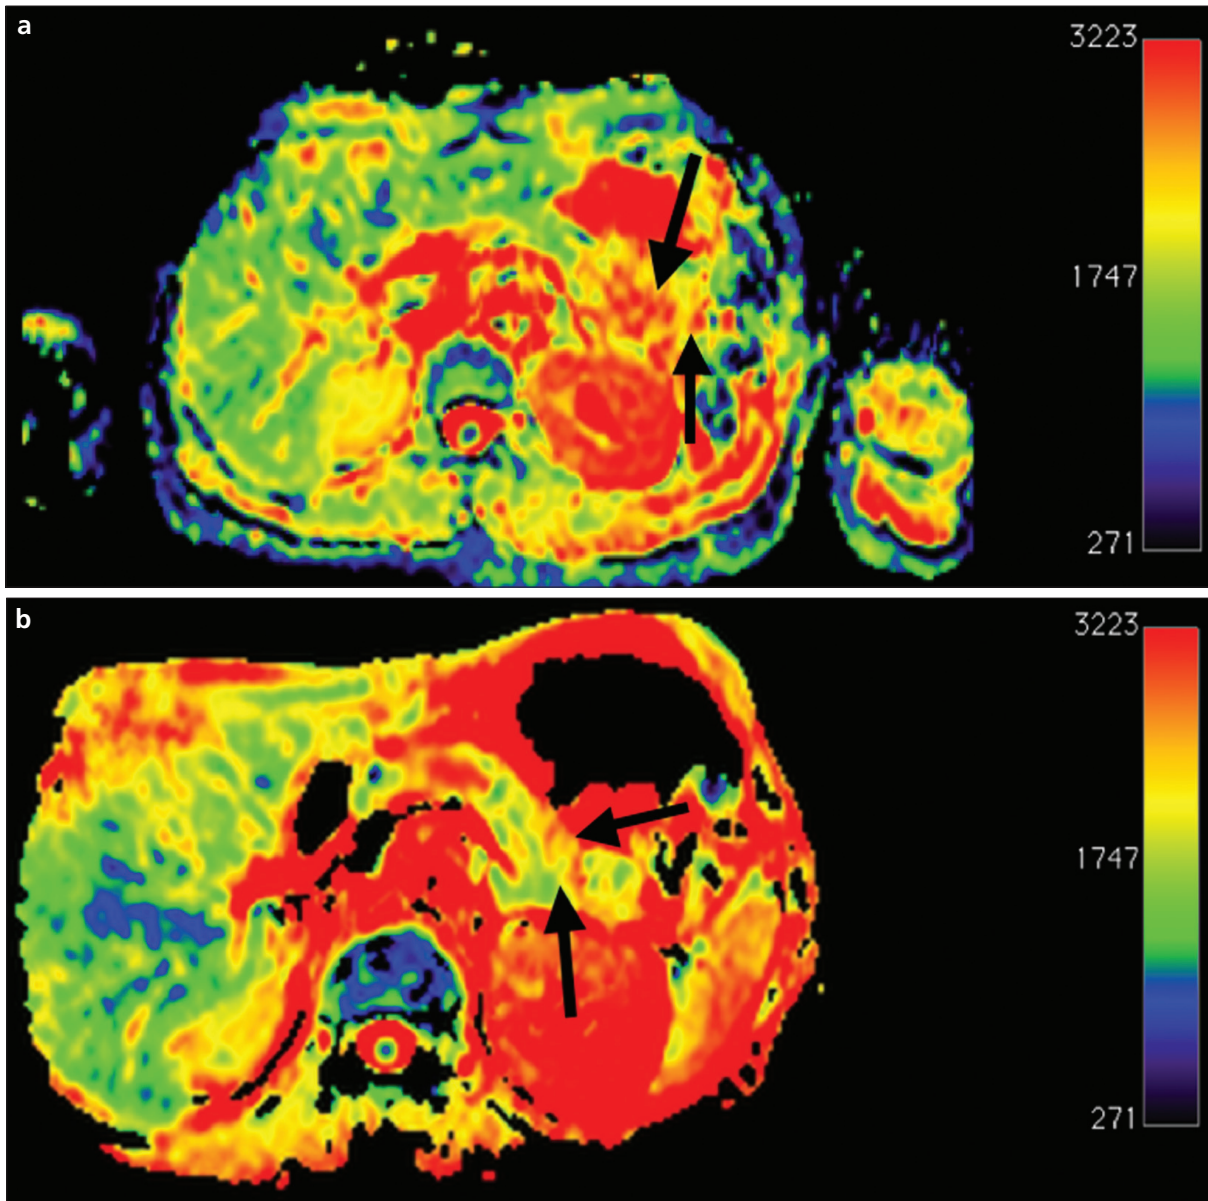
a, b. Colored ADC map derived from diffusion-weighted MRI (DWI) of the pancreas. A normal pancreas with associated ADC values and colors is shown (arrows, a). A patient with clinically established chronic pancreatitis shows decreased ADC values with corresponding colors (arrows, b).
